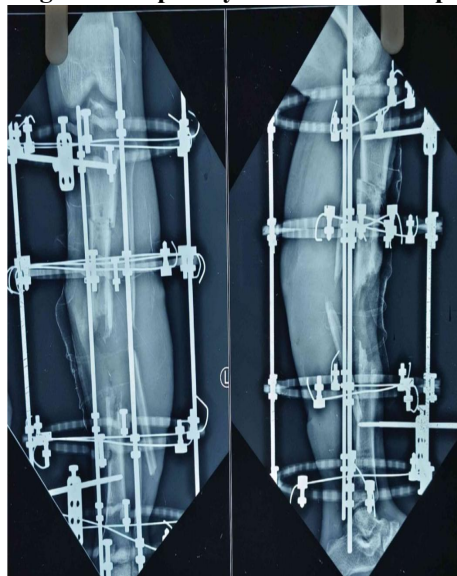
Postop Xray 4 month follow up
